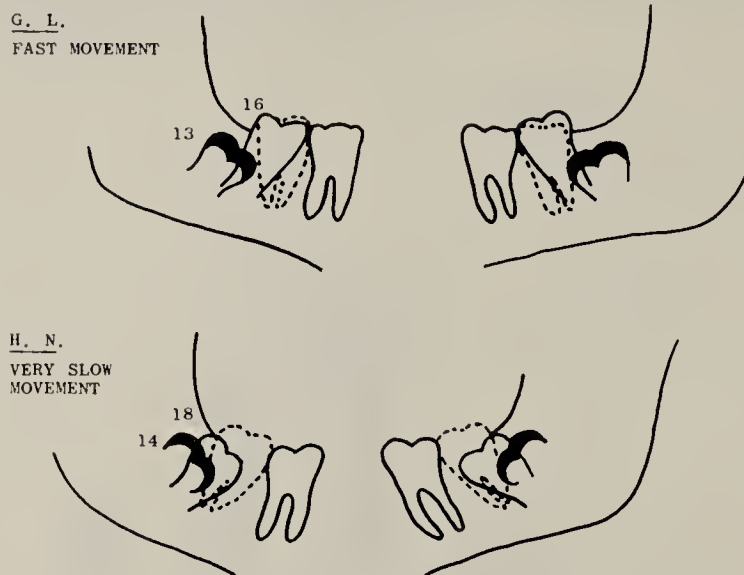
Tracings from radiographs superimposed on $\overline{6|6}$. Position of $\overline{8|8}$ at the time of extraction of $\overline{7|7}$ shown by heavy outline. Broken line shows position of $\overline{7|7}$. Continuous line shows position of $\overline{8|8}$.
